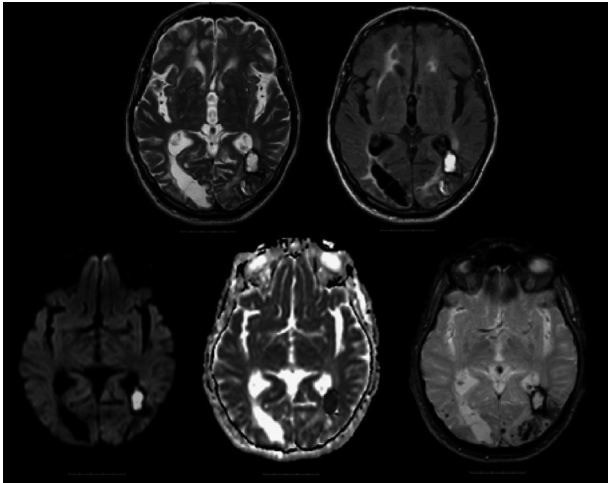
MRI scans from a patient with amyloid angiopathy. Sequences are from left top row: T2, FLAIR; bottom row: DWI, ADC, and gradient echo. An acute haemorrhage is present in the left parietal lobe. Gradient echo GRE is very sensitive to the paramagnetic effect of blood and shows haemorrhage in the left hemisphere as well as some dots in the right. © Anthony Pereira.
